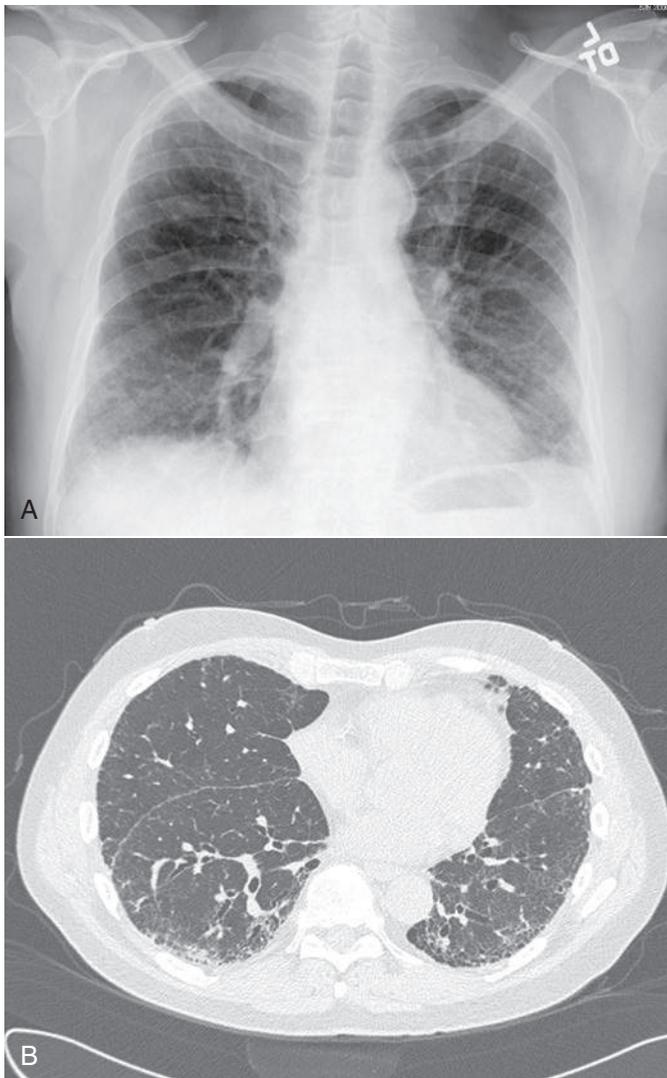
A, Posteroanterior chest radiograph showing the characteristic features of idiopathic pulmonary fibrosis, a common interstitial lung disease. Notice the bilateral lower zone reticulonodular infiltrates and the loss of lung volume in the lower lobes. B, Chest computed tomography image shows the peripheral nature of the fibrosis.
